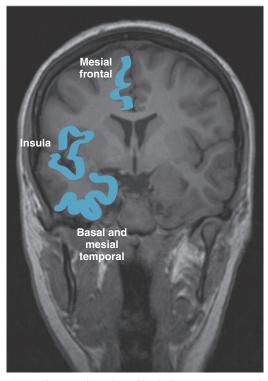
A coronal section of brain is seen on magnetic resonance imaging scan. The mesial frontal lobe, insula, and basal and mesial temporal lobes are highlighted.
